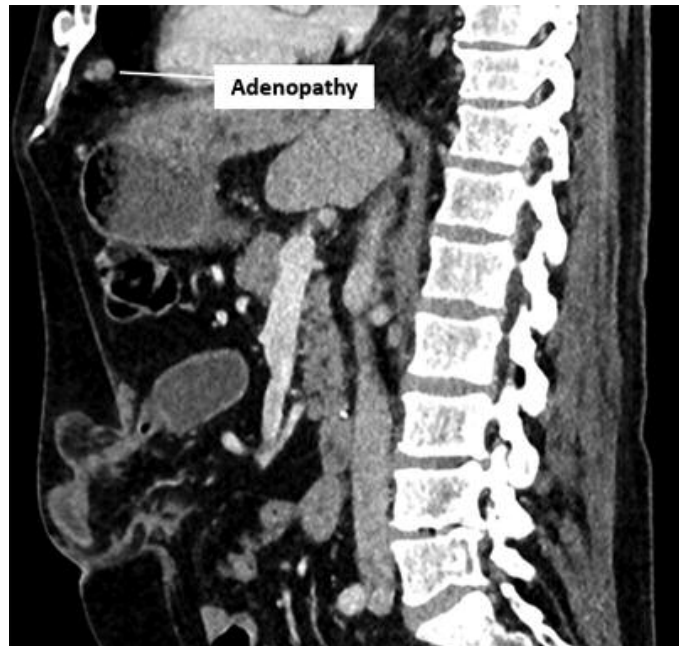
Adenopathy seen on CT scan sagittal plane with contrast.
